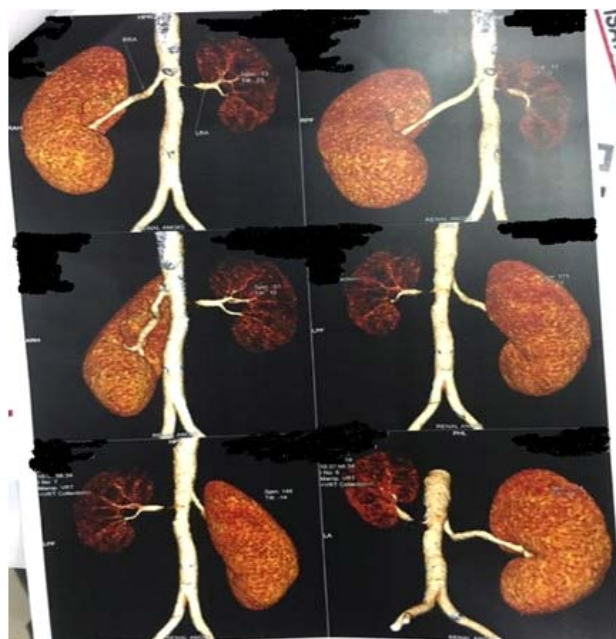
CT Angiogram of abdominal aorta
